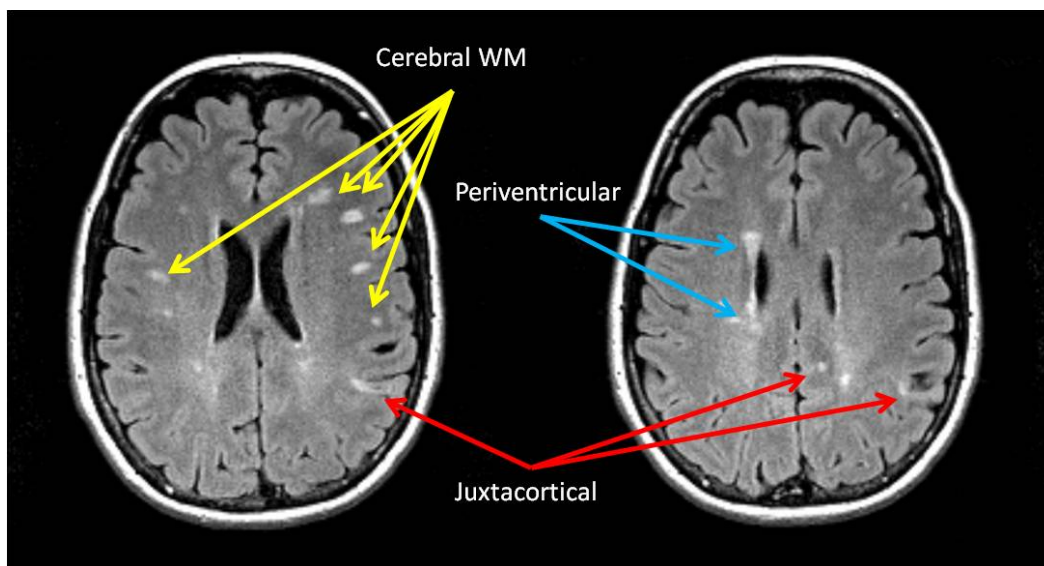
Distribution of T<sub>2</sub>-hyperintensity lesions seen on fluid-attenuated inversion recovery (FLAIR) image. Various sized ovoid and circular shaped lesions seen in the cerebral, periventricular and juxtacortical white matter.
